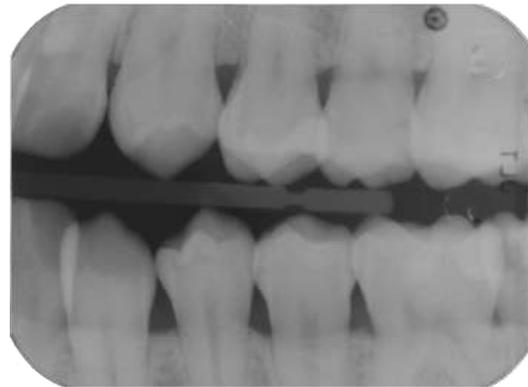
Bitewing Radiograph
